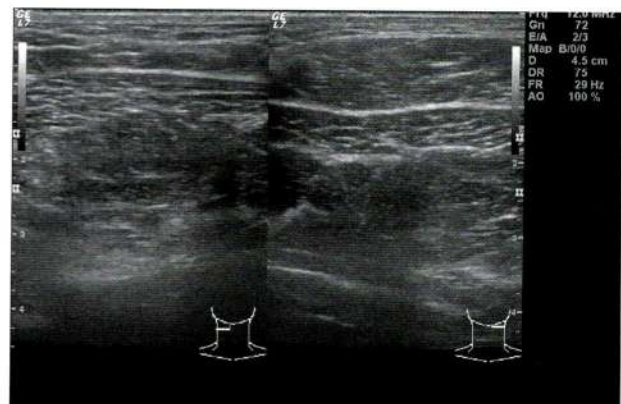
Ultrasound finding showed no definite mass at the posterior necks.
